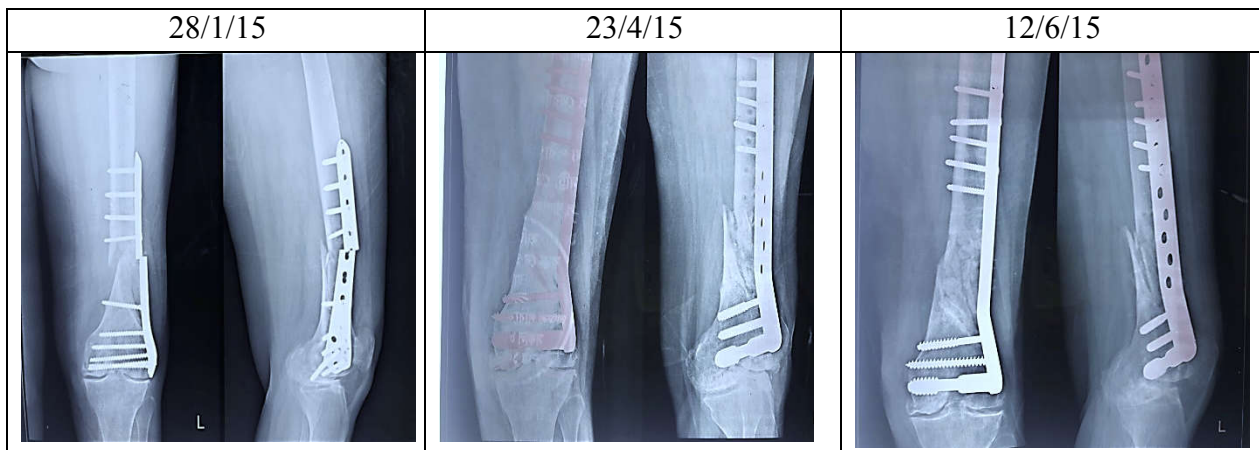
X-ray distal end of left femur antero-posterior view of case 2
